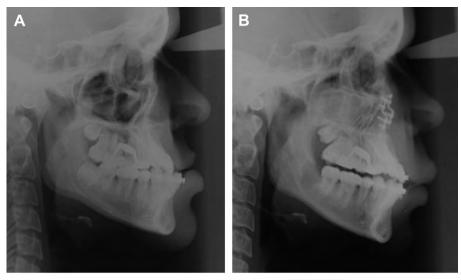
Lateral radiographs show only maxillary anterior and inferior repositioning. Even though the SN-1 was augmented, the facial and smiling esthetics are adequate and no extractions were performed, other than the third molars.
